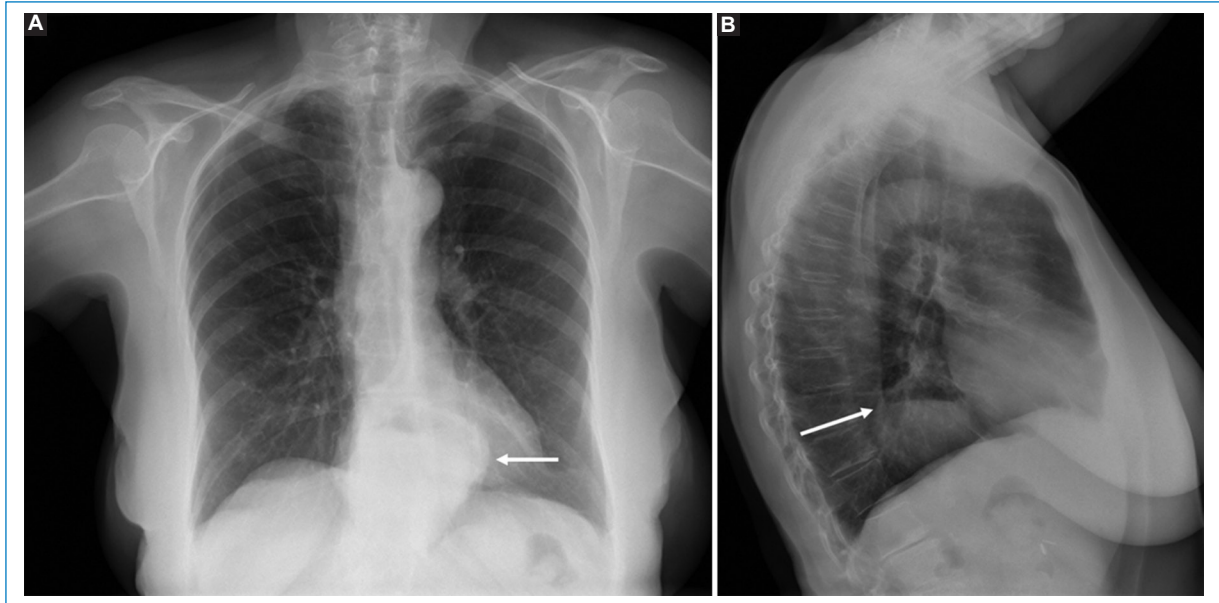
Sliding hiatal hernia. Frontal (A) and lateral (B) chest X-ray. In the retrocardiac region, a rounded opacity with well-defined edges is observed, with an air-fluid level inside (white arrows in A and B).
